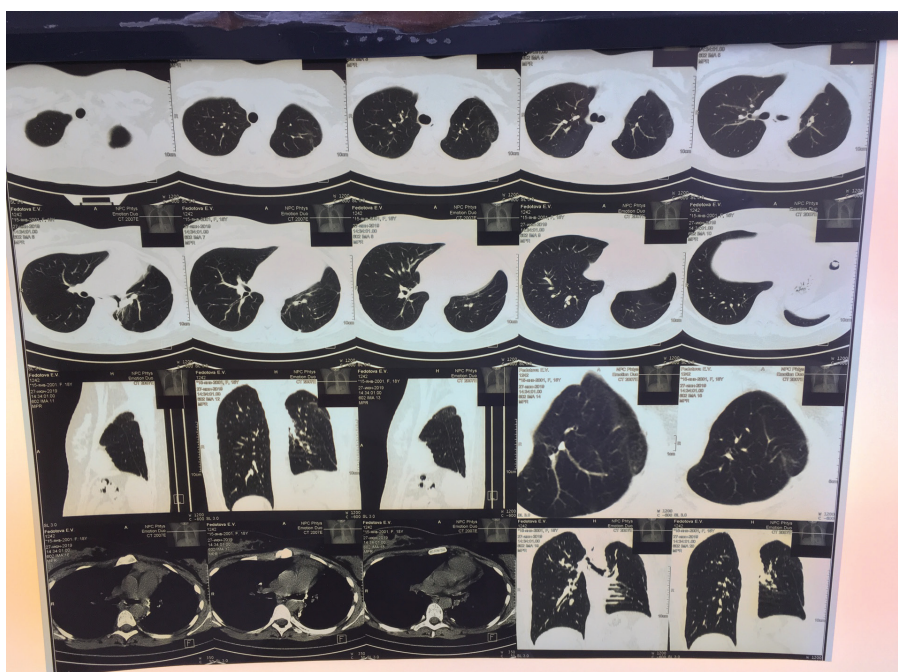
Chest CT scan from June 27, 2019.
